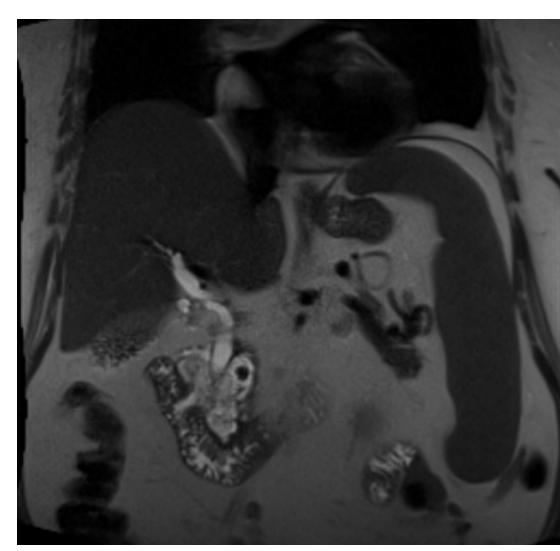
Initial MRI which shows duodenal diverticulum with biliary dilation consistent with Lemmel Syndrome
